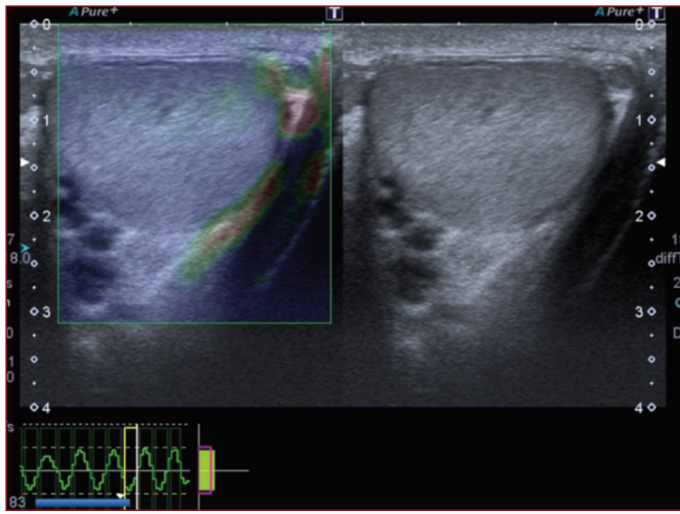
B mode and ultrasound elastography image of the left testis. Velocity profile during compression and decompression.
